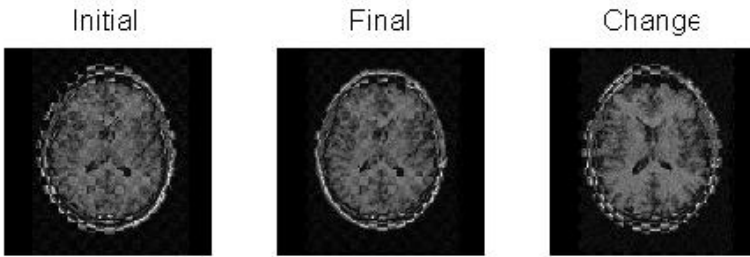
Chequer-board plots showing the different between the initial images of the T1-weighted brains(left), the final images (centre), and the change between the initial and final versions of the free image (right). The registration has lined up the skulls and the major structures within the brain, but there is still more fine-scale work to be done.
